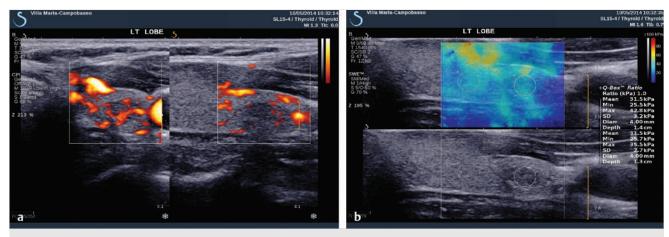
Follicular hyperplasia. (a) SuperSonic Imagine imaging: lesion is located in the lower pole of the left lobe, which appears slightly hypoechoic with a few intranodular vessels at power Doppler. (b) At shear wave elastography the lesion presents similar values of stiffness as the surrounding normal parenchyma.
